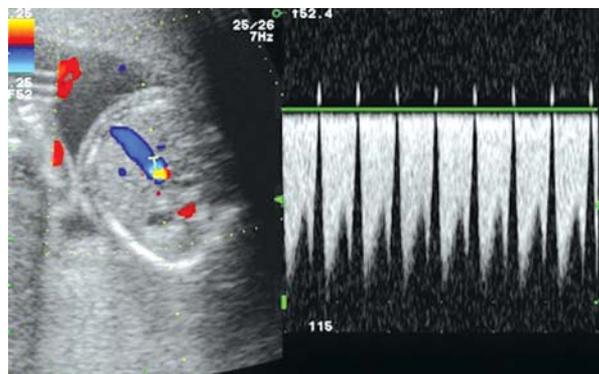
Doppler waveforms in the recipient fetus complicated with twin-twin transfusion syndrome stage 3. Reversed flow in the ductus venosus
